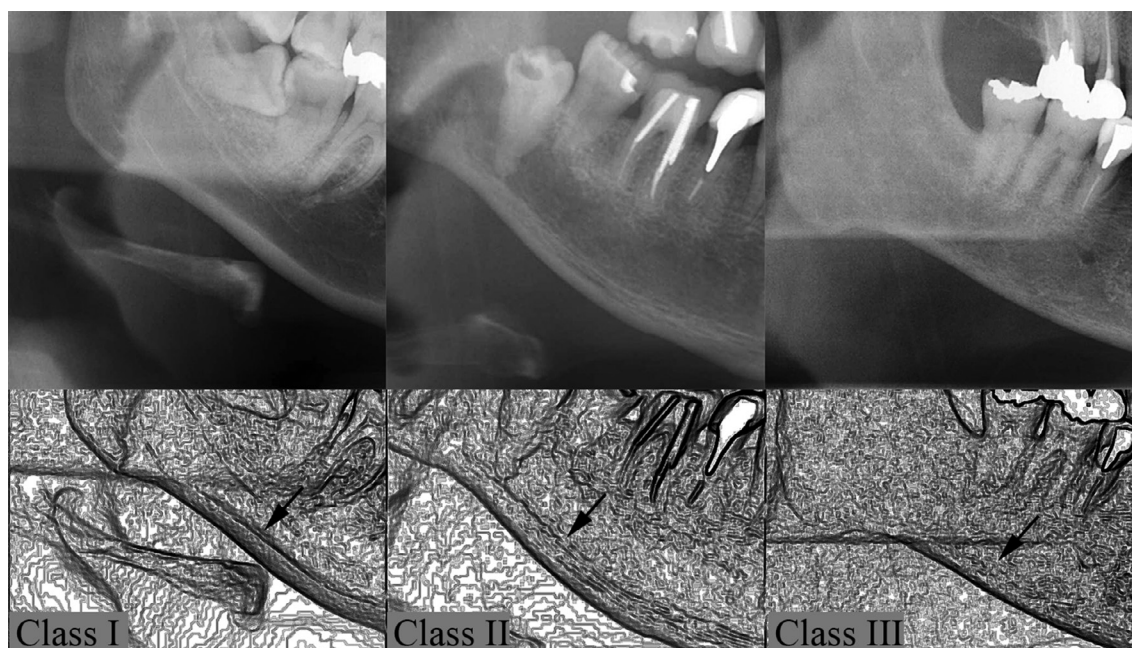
Cropped panoramic radiographs demonstrating three mandibular cortex index classes. Class I: Normal cortex with a continuous cortical outline Class II: Mild to moderately eroded cortex showing an interrupted cortical outline Class III: Severely eroded cortex containing a very ill-defined outline
